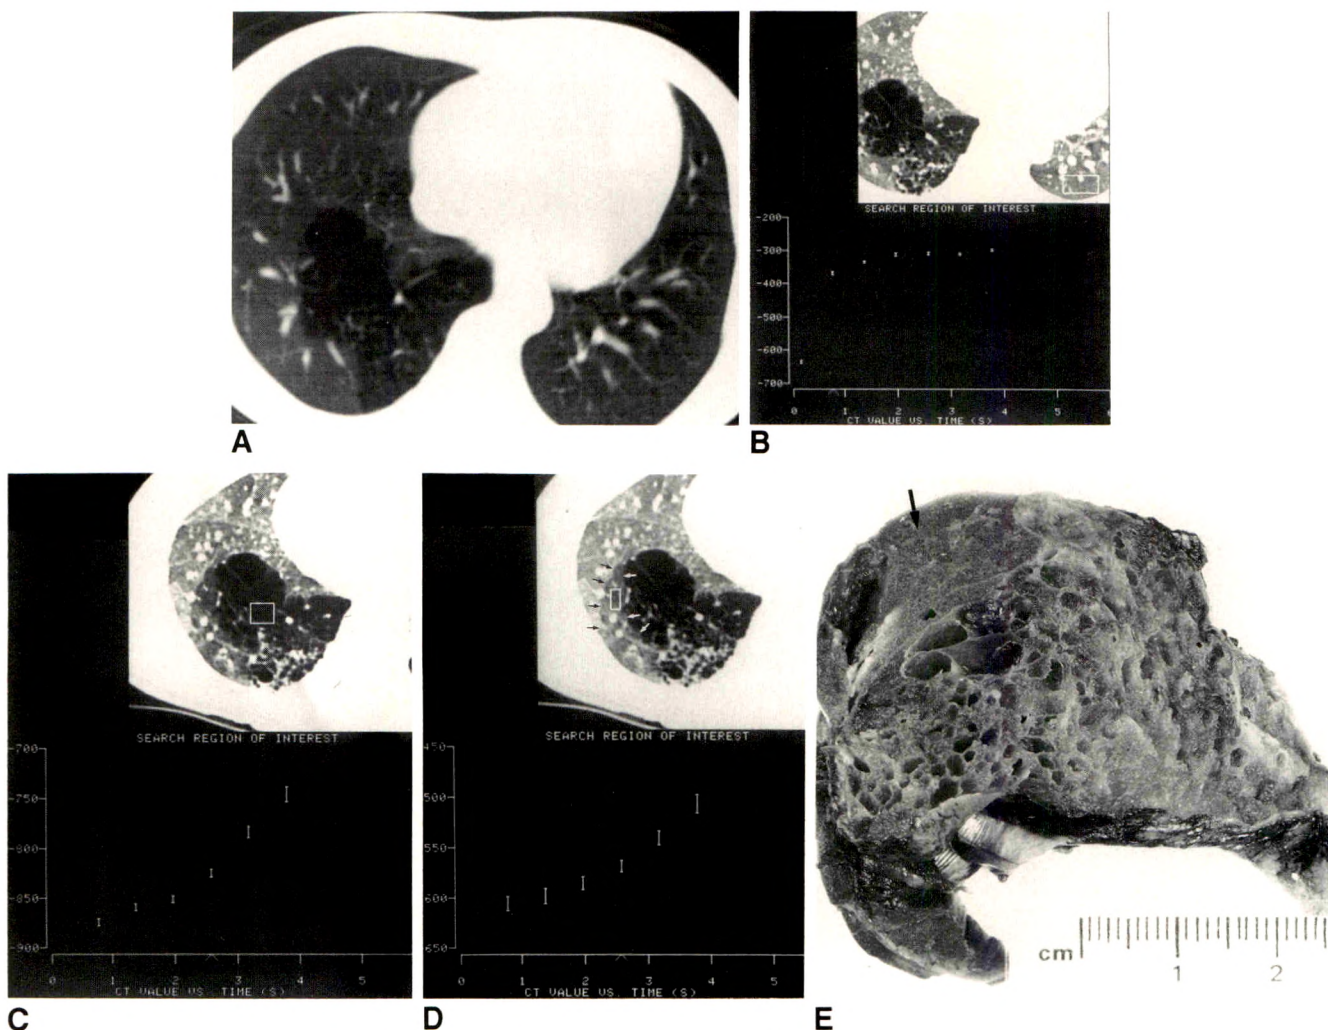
A, Conventional CT scan at level of right lung base. A nonsegmental area of hyperlucency is visible. Cystic components of sequestration are poorly seen.
